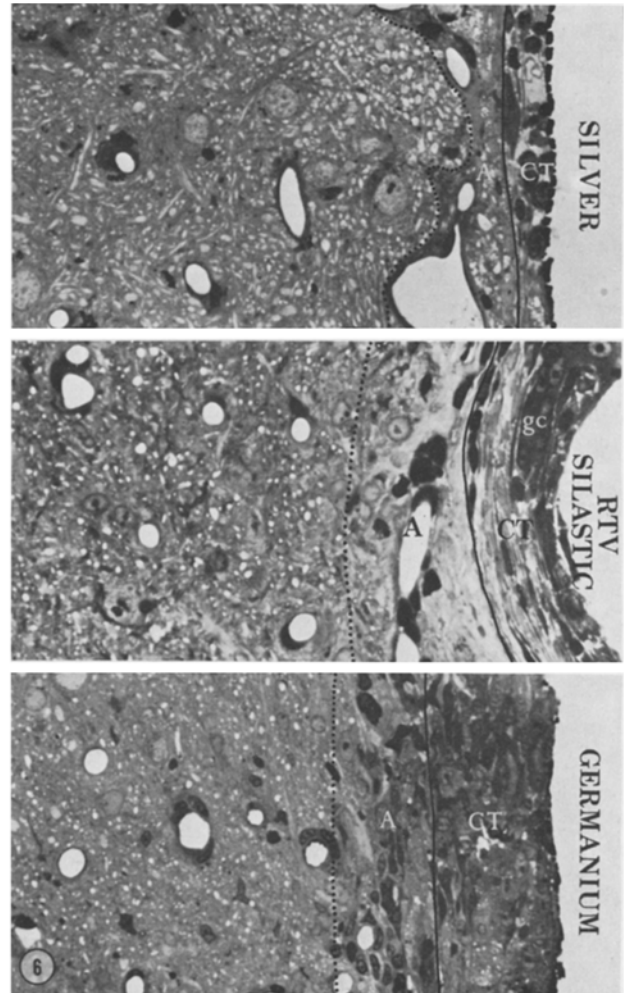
The brain-implant boundary of moderately toxic implants is marked by a zone of astrocytosis (*A*) and connective tissue (*CT*) containing giant cells (*gc*). Altered cerebral cortex with perivascular cuffing and an increased number of small dark cells surrounds the zone of astrocytosis. Silver (125 days), silastic RTV (188 days), and germanium (220 days). $\times 400$
